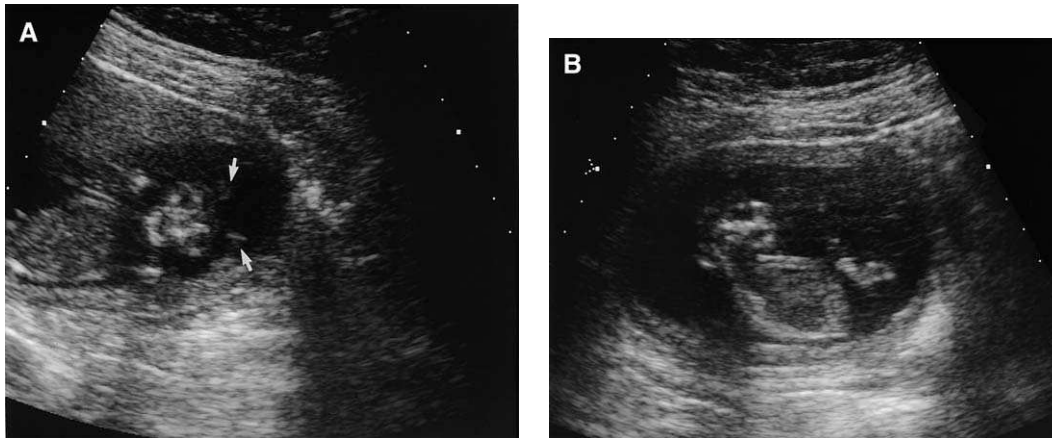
(A) Coronal and (B) sagittal ultrasound of a 12-week fetus with absence of the cranium and separation of the cranial soft tissue into two masses (arrows), which are consistent with anencephaly.
